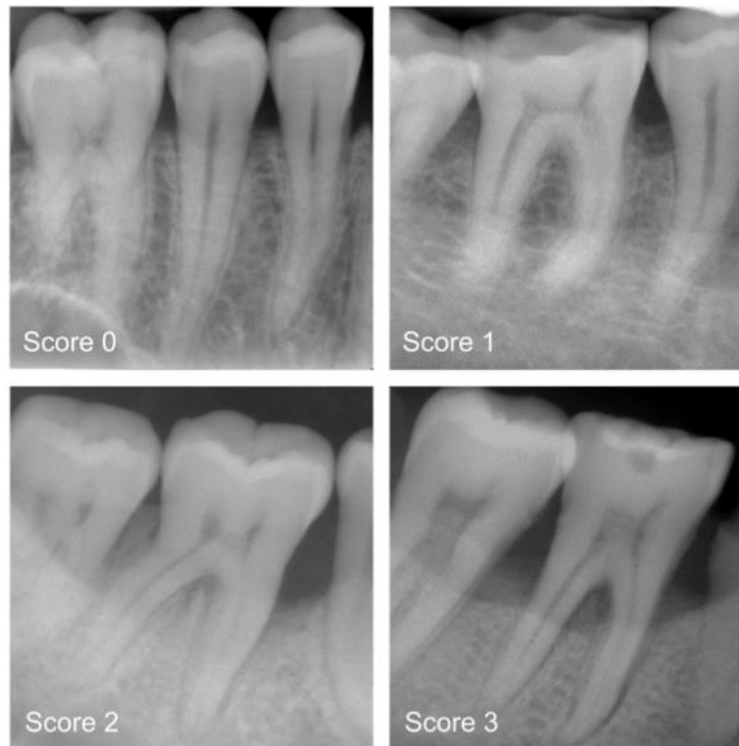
Examples of periapical radiographs for all categories: healthy periodontium (Score 0), mild radiographic periodontal bone loss (PBL) up to 15% of the root length (Score 1), moderate radiographic PBL between 15% and 33% of the root length (Score 2), and severe radiographic PBL extending to the mid-third of the root and beyond (Score 3).
